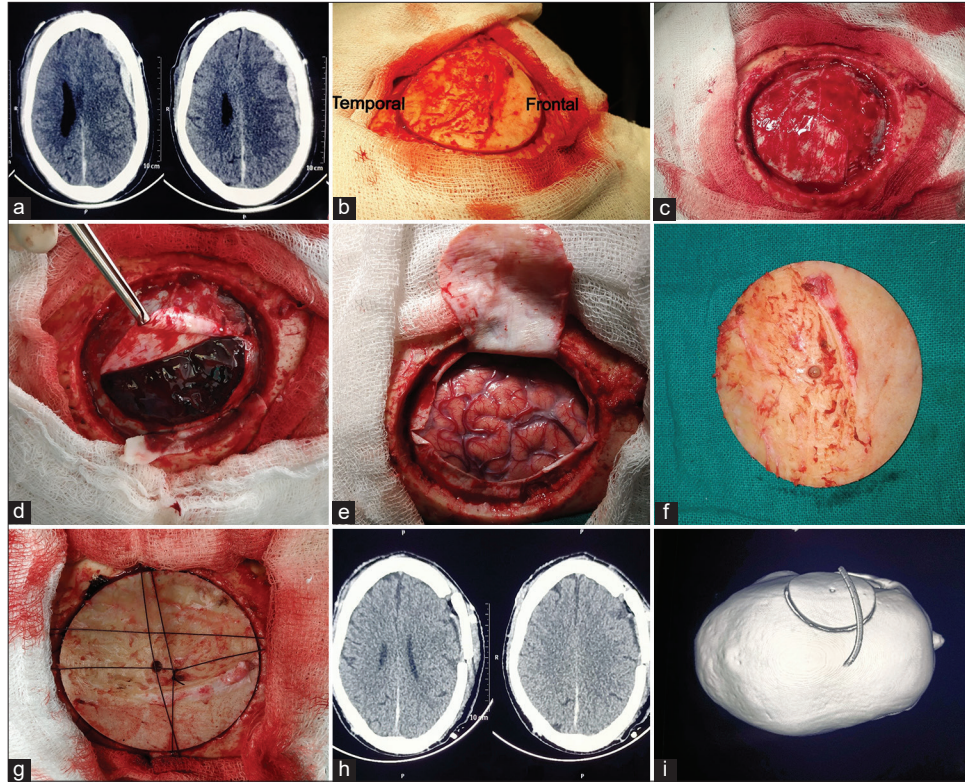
The left-sided frontotemporoparietal acute SDH with mass effect (a), intraoperative view of exposure and trephination (b and c), acute SDH seen (d), SDH evacuated and brain lax (e), bone flap secured using sutures (f and g), postoperative CT shows resolution of SDH and mass effect (h), and 3D bone flap *in situ* (i). SDH: Subdural hematoma.
